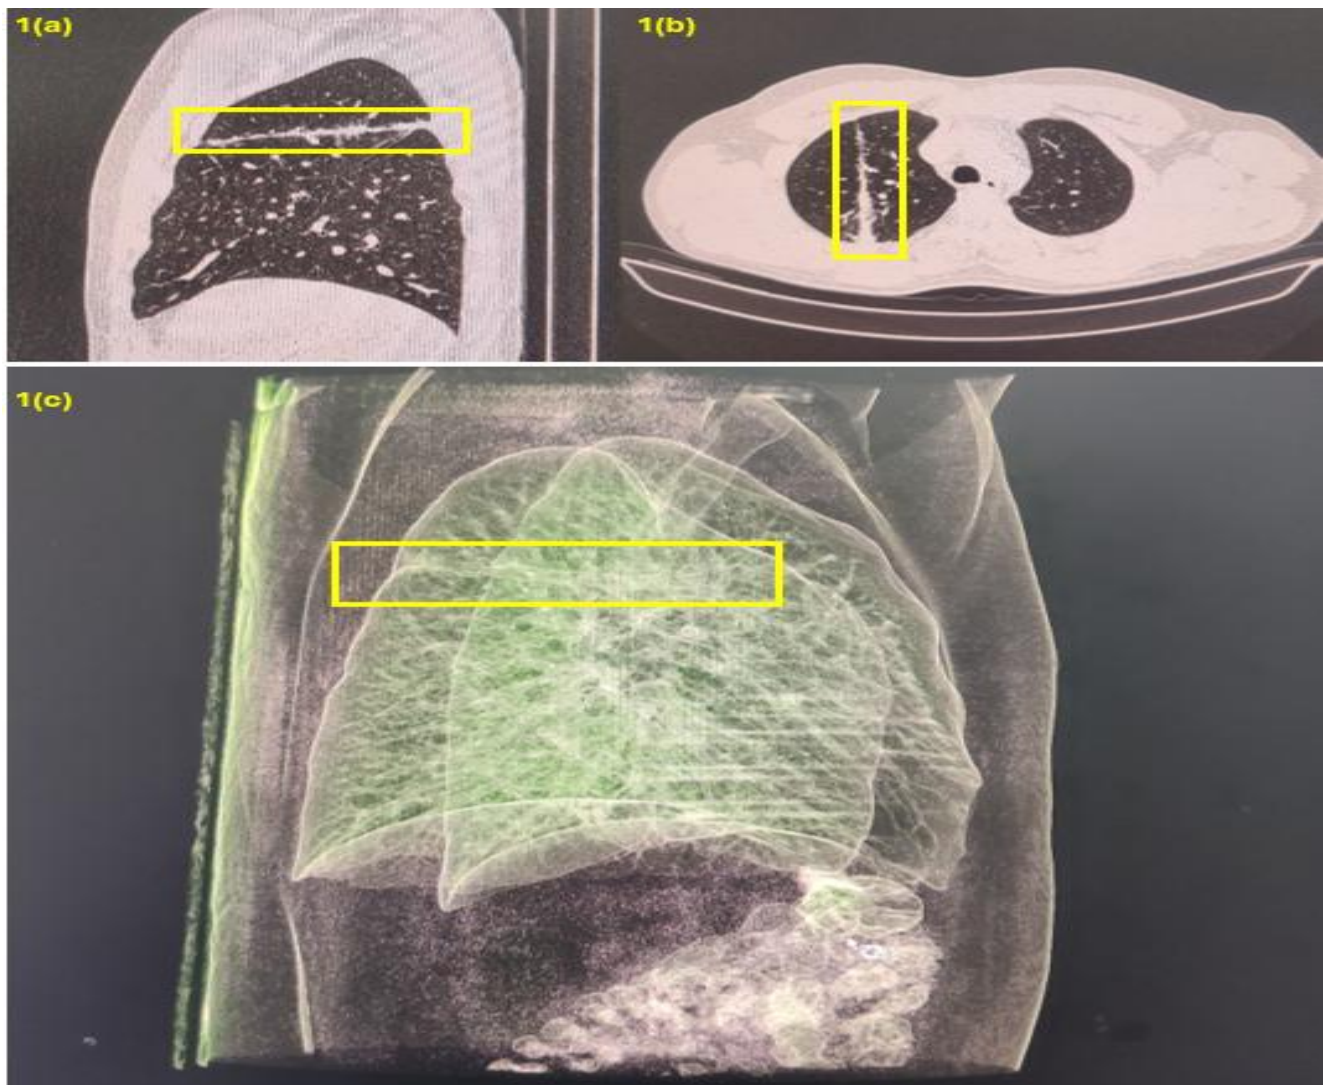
(a) parasagittal, (b) axial section and (c) digital 3-D reconstruction on CT scan showing completely expanded right lung with healed parenchyma and trajectory of (firearm) injury.
